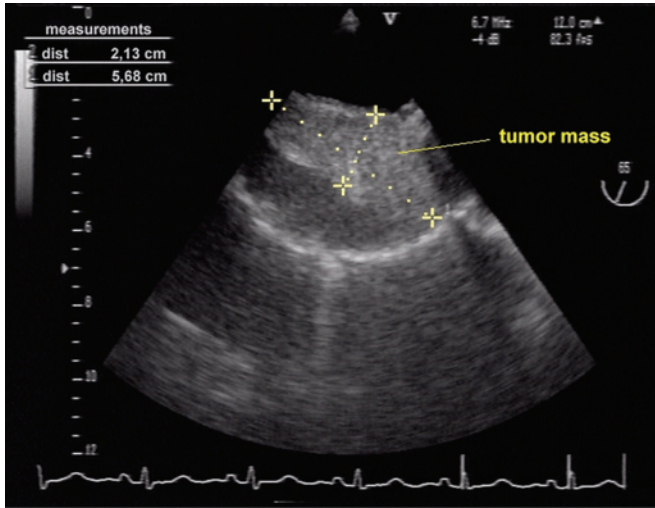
Transesophageal echocardiography showing the right atrium mass on the superior aspect of the atrial septum.
